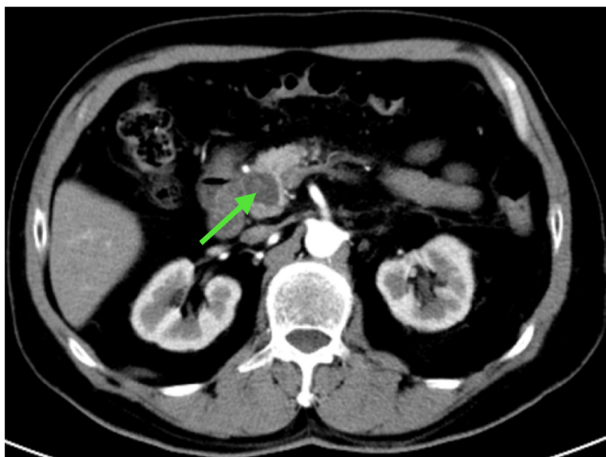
Enhanced computed tomography scan showing the enhanced edge of the shadow, with no enhancement inside (arrow).
